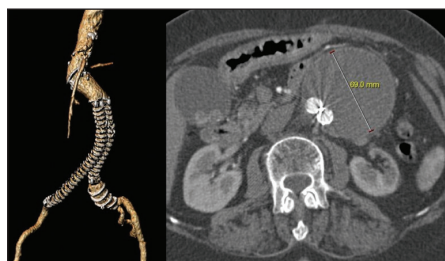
CTA at 1 month.
